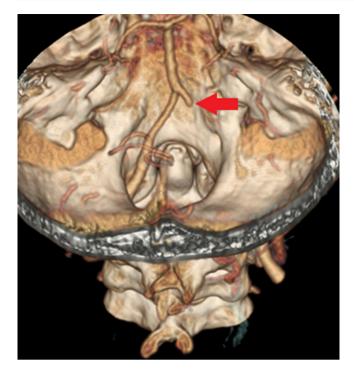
CT angiogram demonstrating occlusion of the left vertebral artery.
